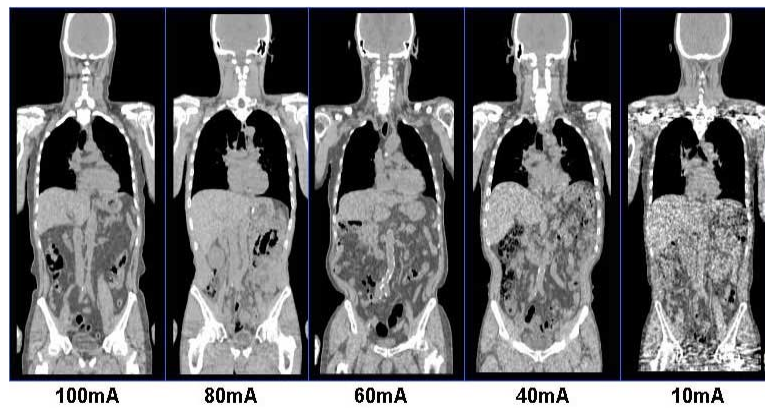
CT images acquired with various tube currents.
